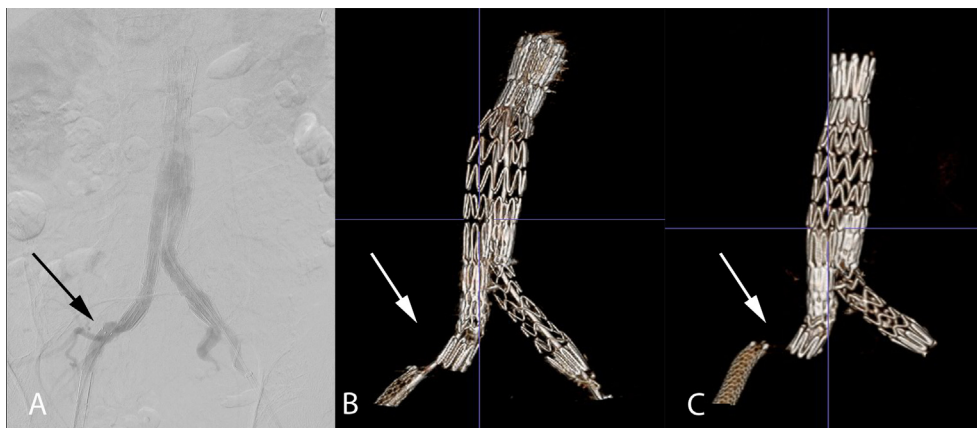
Mis-alignment between the stents in the right iliac. (A) Completion angiography. The black arrow displays the area of interest. (B) Cone beam computed angiography (CBCT). The white arrow clearly shows kink between the iliac limb and the native artery. (C) Follow up computed tomography angiography (FU CTA) displays the same finding as the intra-operative CBCT. Note the effect of the absent guidewire when comparing CBCT and FU CTA.
